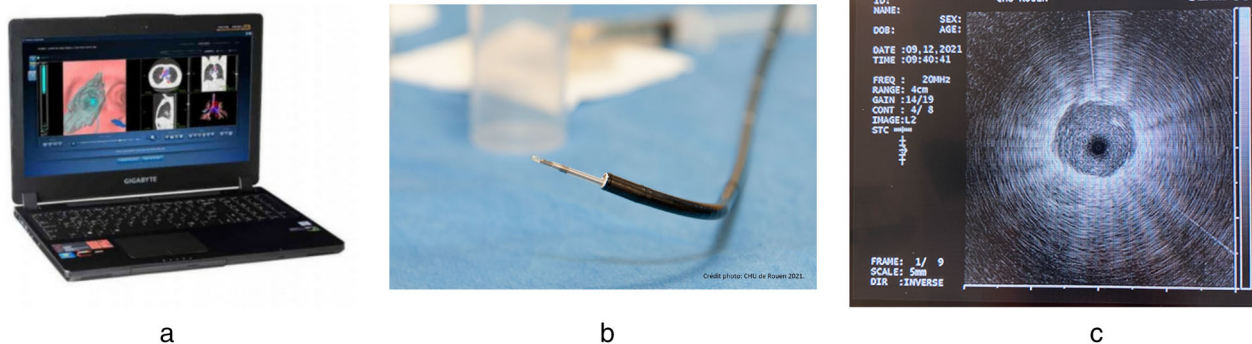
(a) Virtual bronchoscopy planner (LungPoint, Broncus Medical Inc.). (b) A 4 mm scope (MP160F video bronchoscope or a BF-MP60F bronchofiberscope (Olympus)). (c) Radial-endobronchial ultrasound (EBUS) image with ultrasonic image of a nodule
